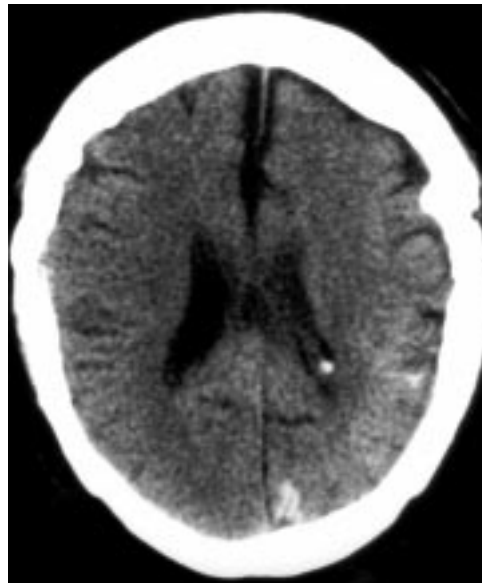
Axial contrast CT brain scan
